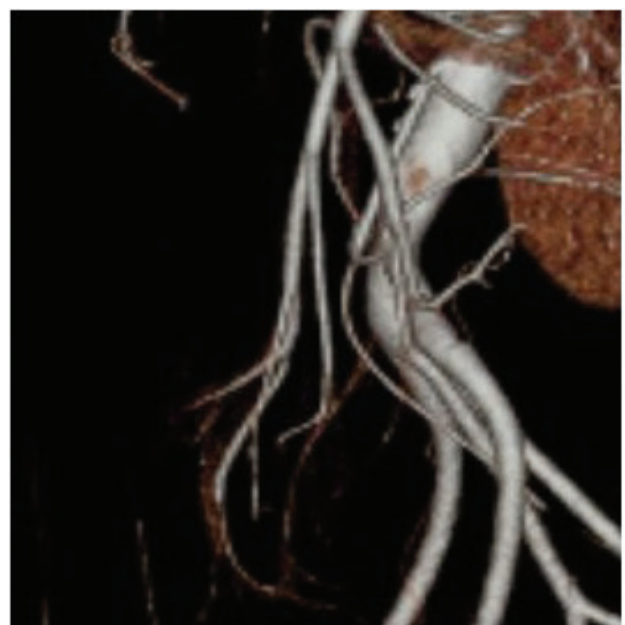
Postoperative control computed tomographic angiography.
